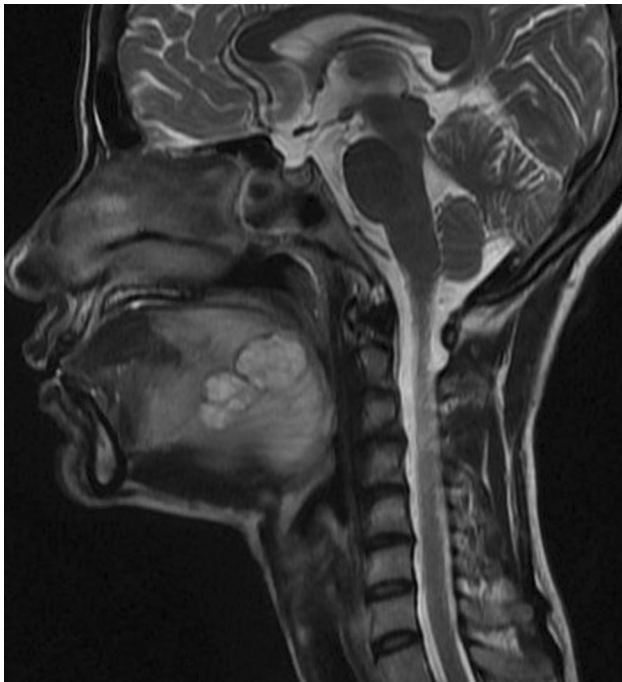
MRI of tongue showing homogeneously enhancing mass in right half of tongue, middle and posterior third area
